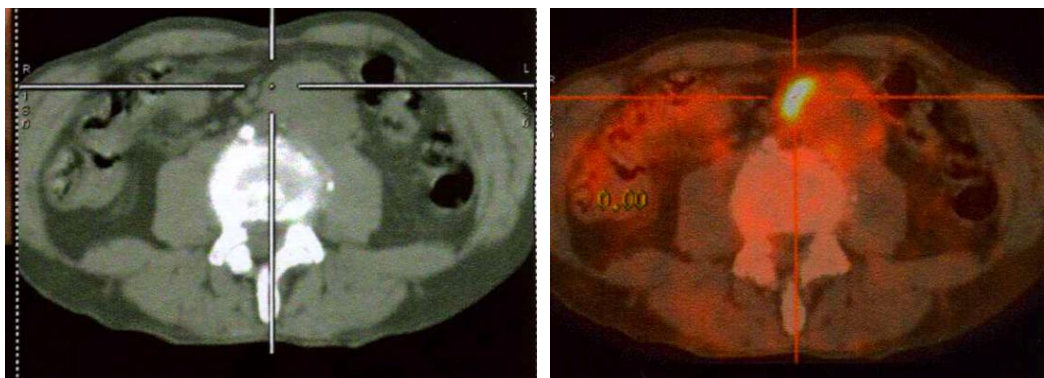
Small unstable abdominal aortic aneurysm (AAA) with 18F-Fluorodeoxyglucose (FDG) uptake. Left: Computer tomography (CT) scan. Right: positron emission tomography (PET).
